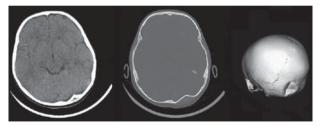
CT imaging of a left occipital depressed skull fracture using conventional windowing (left). The fracture is more obvious on the bone window image (centre). Spiral CT reconstructs a 3D image of the skull and the fracture is clearly visible (right). Note that axial CT (and MR) images are conventionally orientated 'as if looking up from the feet' and thus a left-sided fracture appears on the right side of the image.
